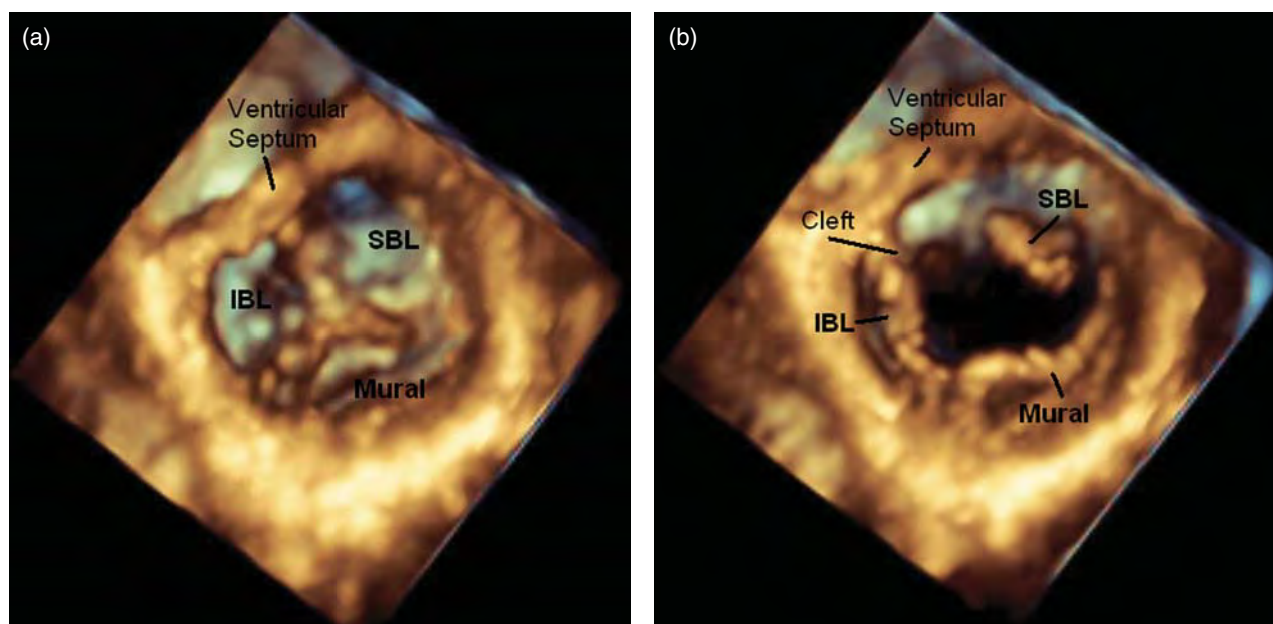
(a) Three-dimensional (3D) echocardiographic image cut from the left ventricle looking up toward the left atrioventricular valve in a patient with incomplete common atrioventricular valve. In the closed position, the trifoliate appearance of the valve is highlighted well. (b) Same image with the left atrioventricular valve in the open position shows the leaflets well with the “cleft” seen directed toward the ventricular septum. IBL, inferior bridging leaflet; SBL, superior bridging leaflet.
